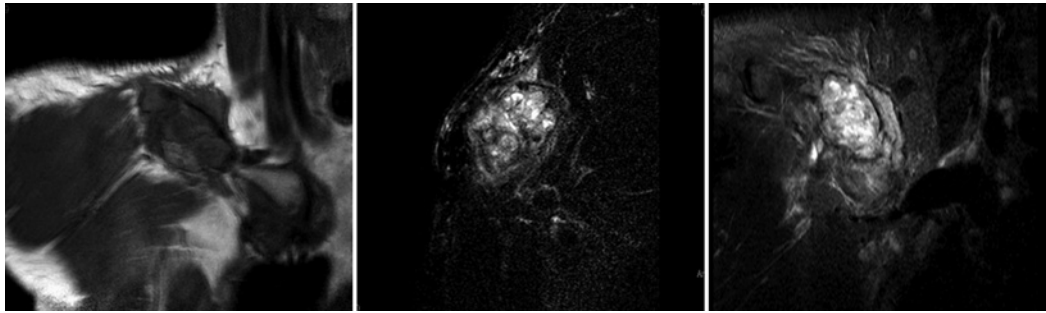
Magnetic resonance imaging eliciting an isointense appearance lesion in T1-weighted imaging and a hyperintense appearance in T2 with a lobulated heterogeneous caption pattern after contrast enhancement.
